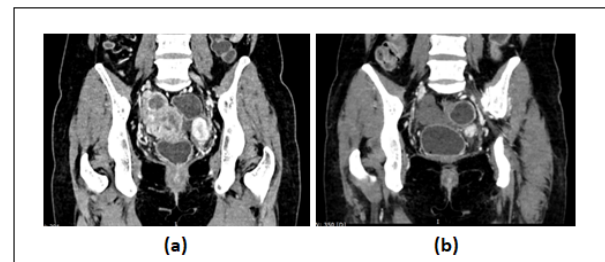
Abdominal CT Scan. (a) A fairly defined isodense soft tissue mass in the pelvic region approximately measuring 4.4 x 6.8 x 8.3 cm and 2.5 x. (b) A fairly defined isodense soft tissue mass in the pelvic region approximately measuring 4.4 x 6.8 x 8.3 cm and 2.5 x
